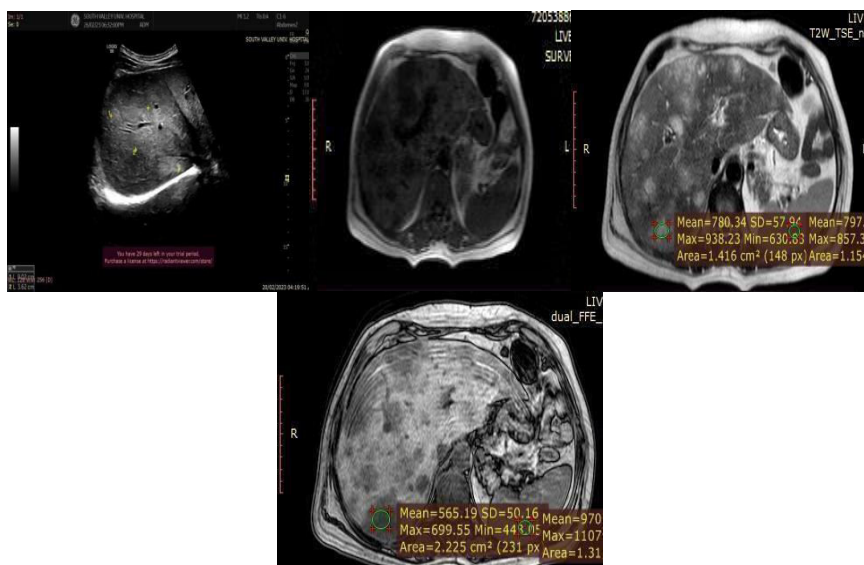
A 50-year-old non-diabetic female patient whose BMI was 19 kg/m² presented with upper abdominal pain.. liver enzymes were mildly elevated, SGPT= 117U/L , SGOT =500U/L , total bilirubin =0.38 mg/d Abdominal ultrasound showed focal fatty liver infiltration MRI showed focal fatty infiltration with MRI Liver Steatosis \pm 26.9
